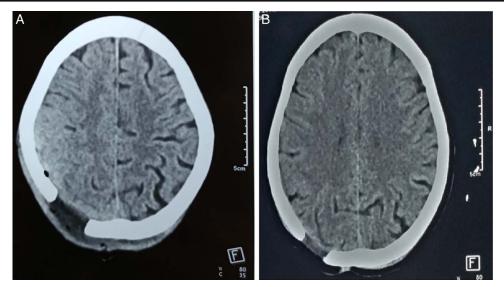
Postoperative computed tomography head on the fifth (A) and thirty (B) day showing cranial defect and resolution of subgaleal and epidural collection.
